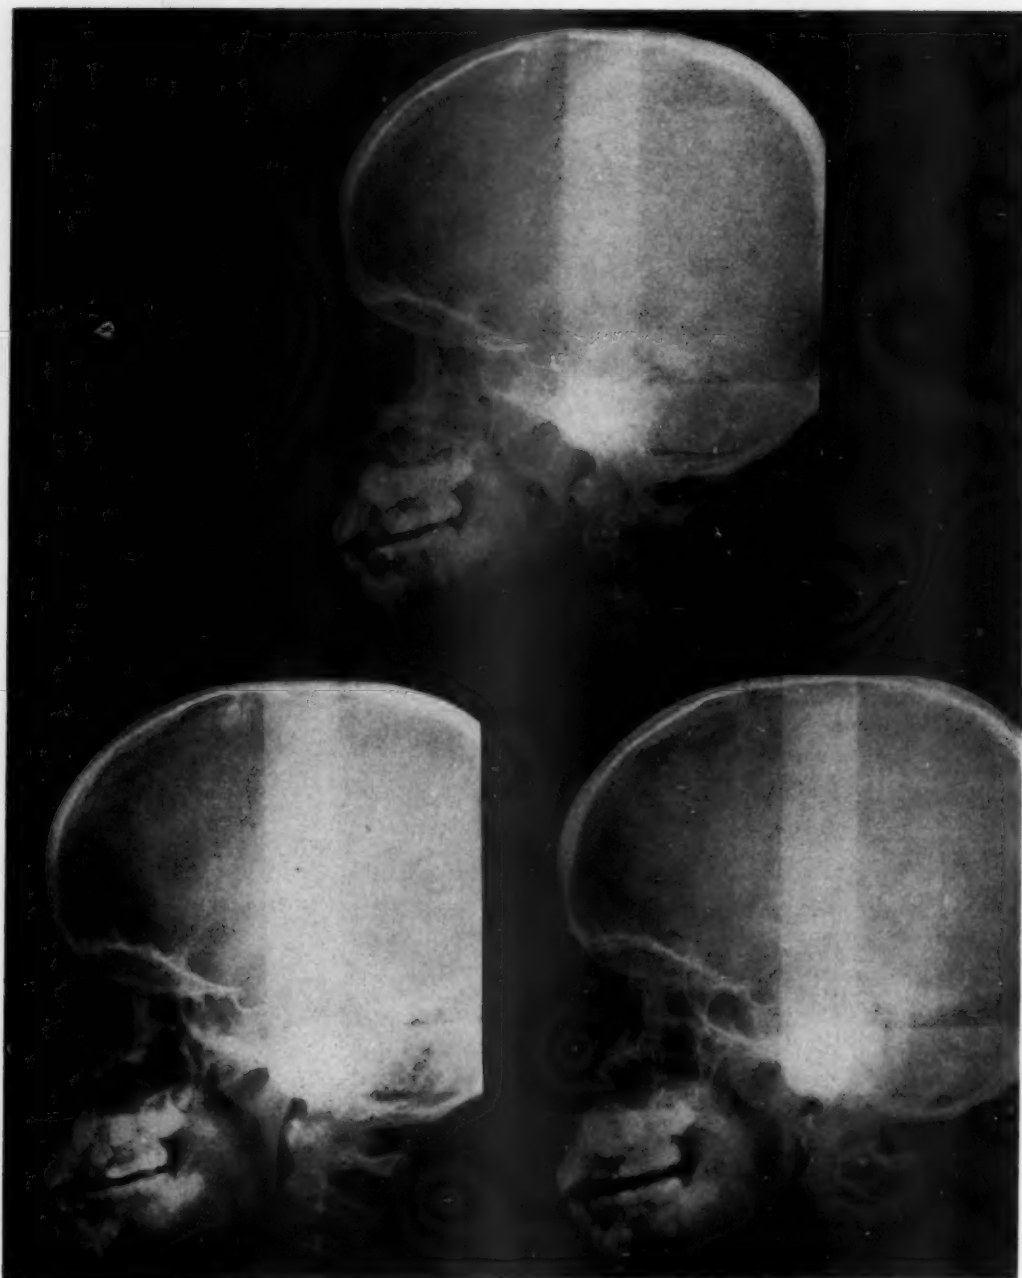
Broadbent profile x-rays of triplets, showing the congenital absence of mandibular second premolars in all three children.
